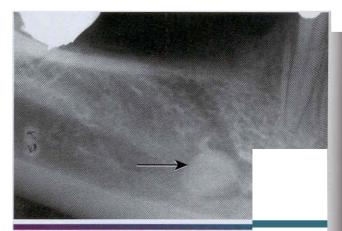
• Sialolit hiasis. Periapical film of the same saldith as depicted in Figure ''-13. A radiopacity (arrow) is superimposed on the mandible. Care must be taken not to confuse such lesions with intrabony pathosis.
